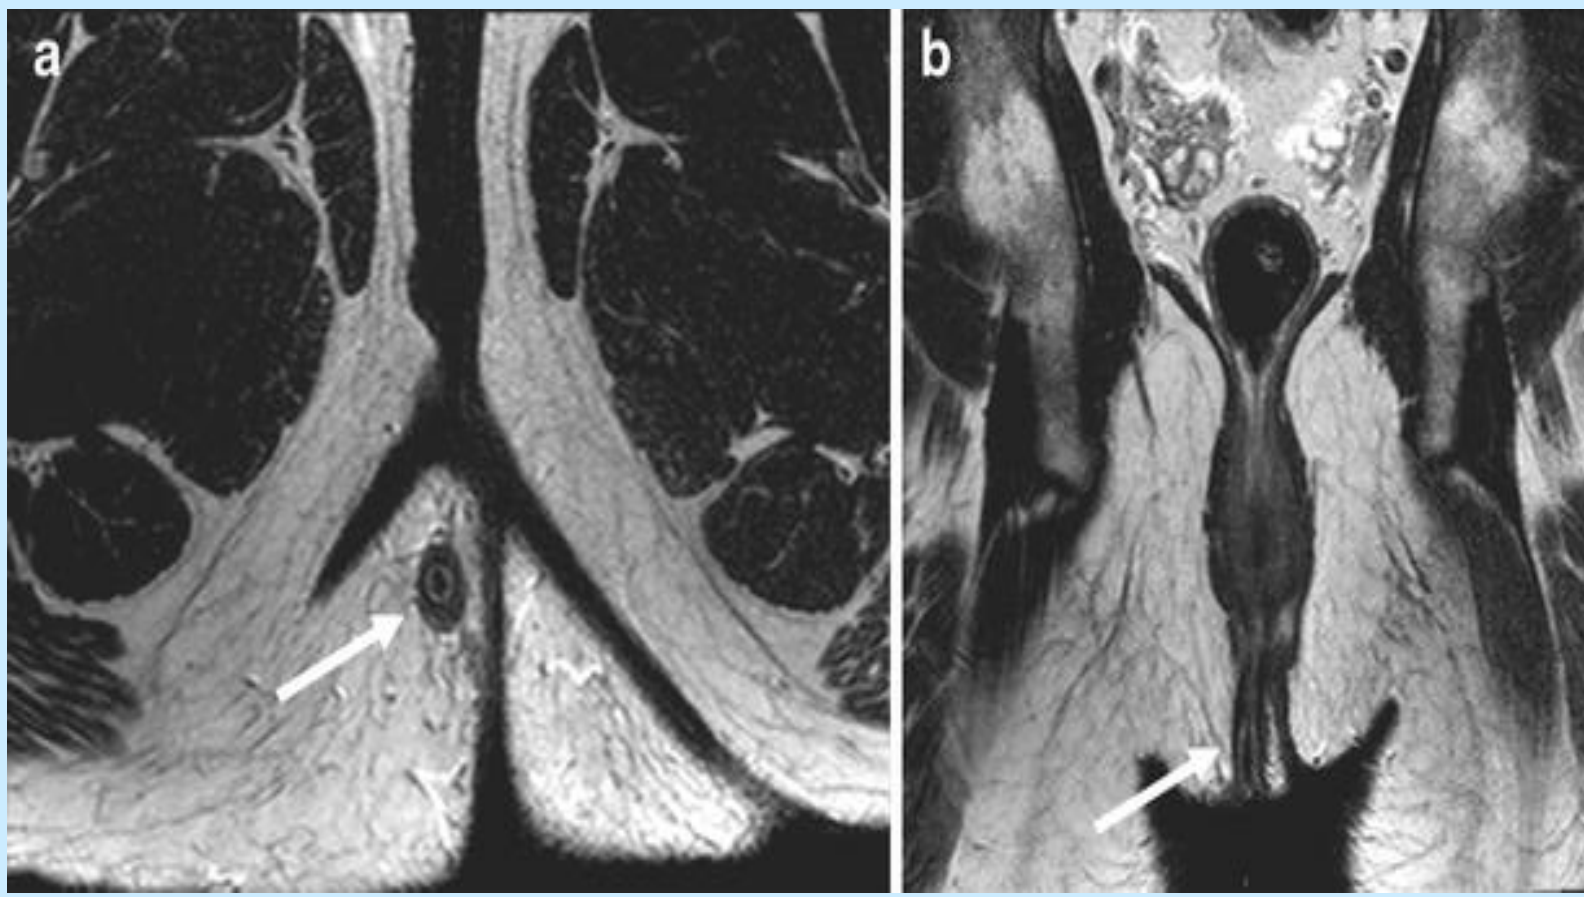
Sagittal (a) and coronal (b) T2-weighted images of a patient treated with seton at follow-up. The seton is seen as a dark inner structure in the middle of the fistula (white arrows)
